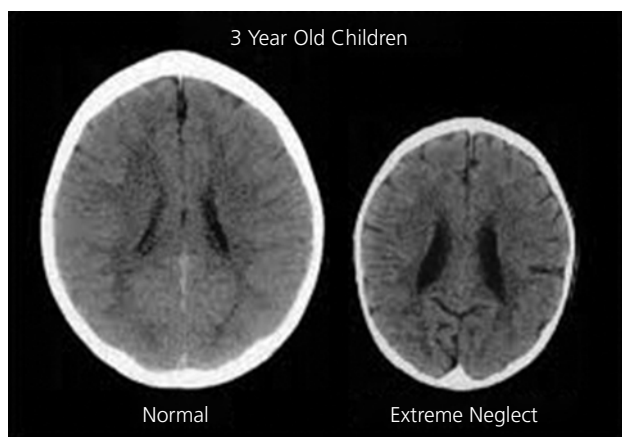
Abnormal brain development following neglect in early childhood: The CT scan of a healthy 3 year old (left) and a 3 year old suffering from severe sensory-deprivation neglect, showing microcephaly, enlarged ventricles and cortical atrophy. *Source:* Permission obtained from Springer Nature.
